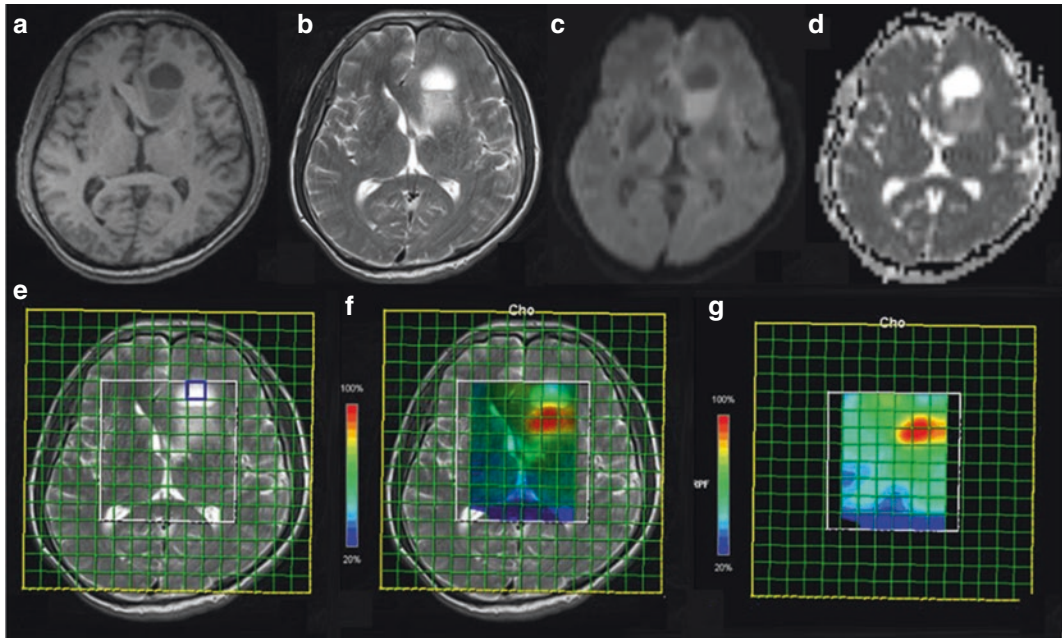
A 67-year-old male patient admitted with recurrent seizures for >1 month; postoperative pathological diagnosis: glioblastoma in the left frontal lobe with IDH mutation, WHO grade IV. The pre-operative MRI (a–d)
